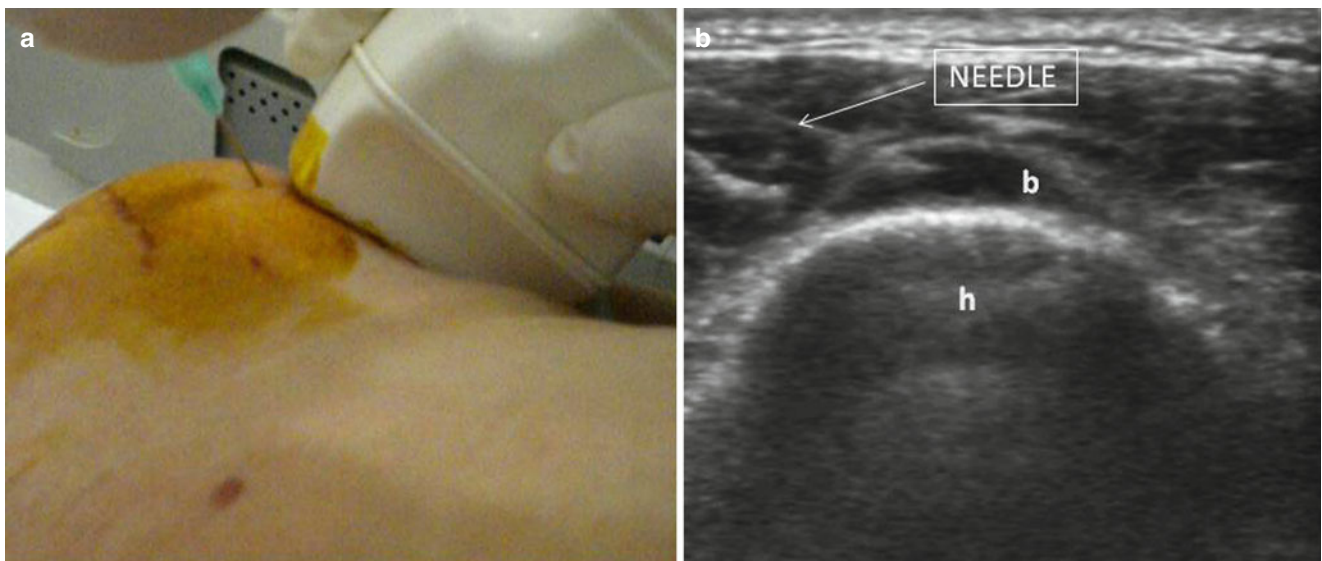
(a) Ultrasound-guided intra-bursal injection from the anterior approach of the shoulder. The needle is inserted parallel to the transducer. (b) The needle (arrow) is guided into the bursa (b); humerus (h)
